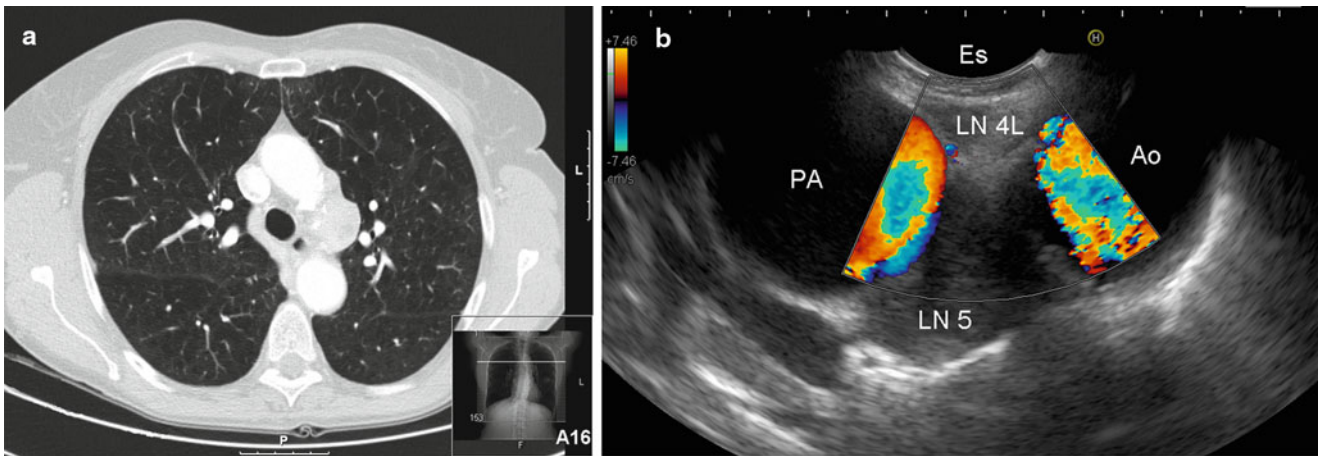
(a) Computed tomography of the chest showing enlarged mediastinal nodes in the aortopulmonary window (station 5). (b) Corresponding EUS image, showing the left lower paratracheal node (station 4L) and the nodes in the aortopulmonary window. *AO* aorta, *PA* pulmonary artery, *ES* lumen of the esophagus
